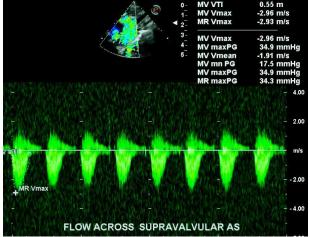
Continuous flow Doppler analysis across the supravalvular aortic membrane. Continuous flow Doppler showed peak/ mean gradient of 34.9/ 17.5 mmHg, suggestive of moderate obstruction.
